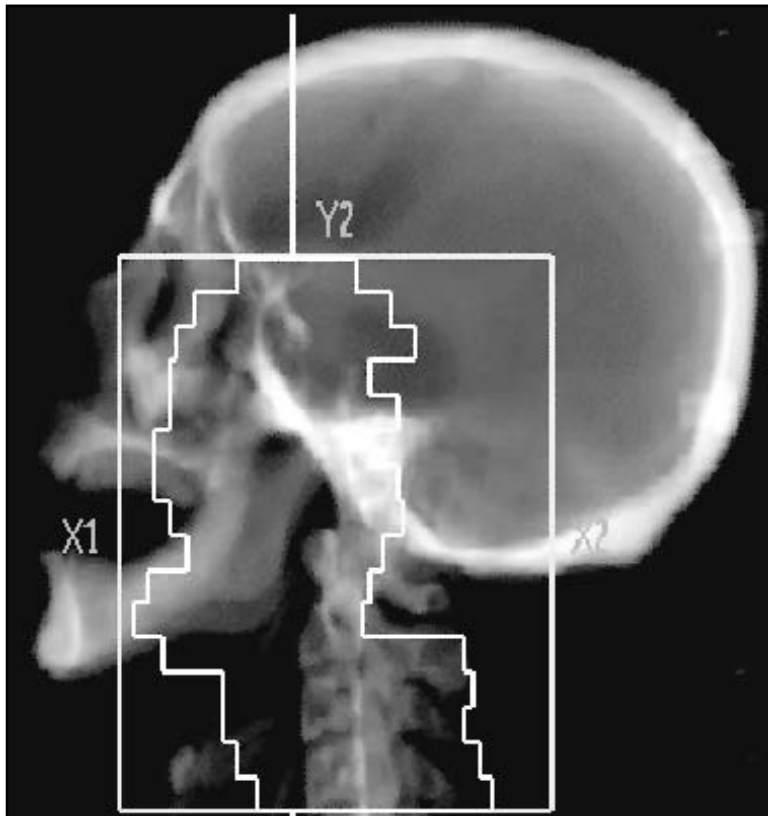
Digitally-reconstructed radiograph (DRR) of a left lateral IMRT field for primary nasopharynx cancer. The aperture indicates the initial and final positions of the MLC leaves used for the dynamic delivery.
